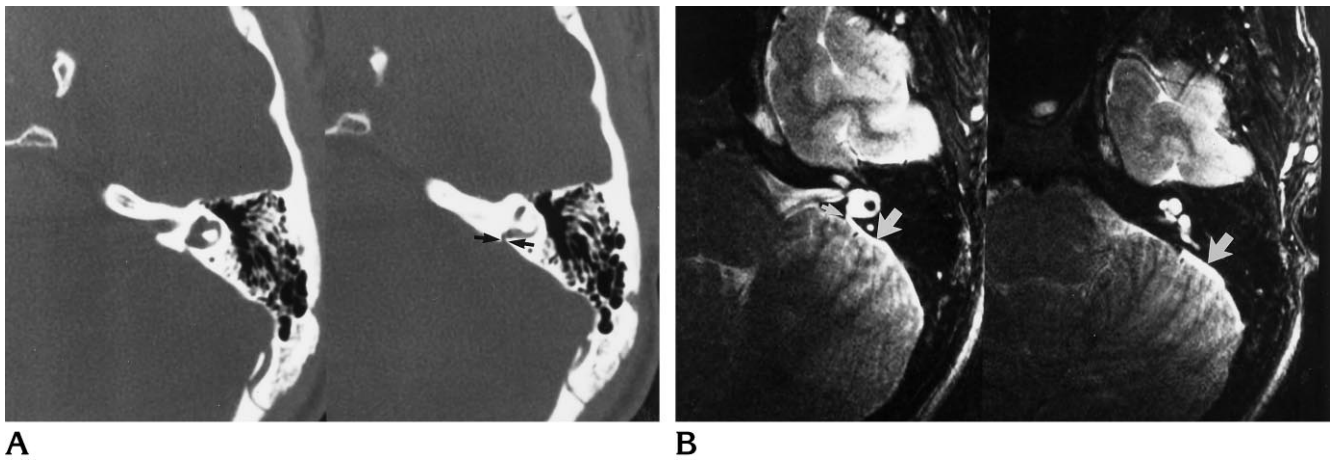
Prominent vestibular aqueduct that is indeterminate on CT but enlarged at MR imaging.
